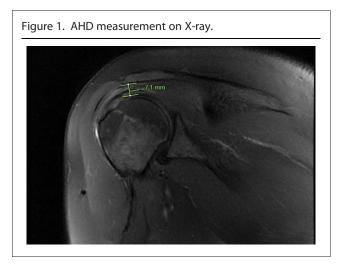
AHD measurement on MRI.
